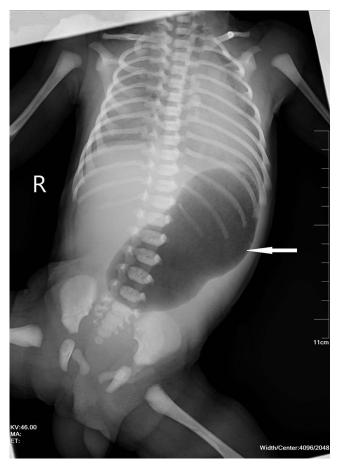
Abdominal X-ray reveals a single gas bubble in a distended stomach with no gas detected in the distal portions, indicating pyloric atresia (PA).
